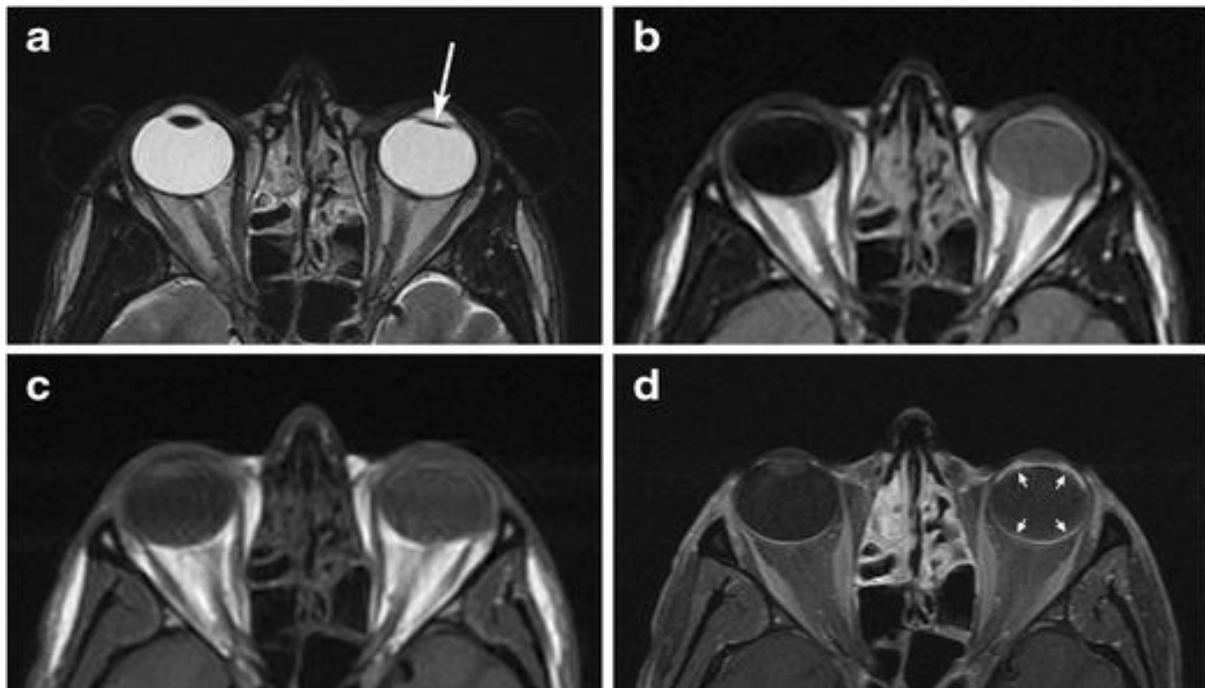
Panuveitis in patients with a - d ankylosing spondylitis. Improved axial T2WI (a), axial (a), FLAIR (b), T1WI (c), and T1WI images in which luma and saturation (d) show a balance between water and glass, and increase the light of gadolinium - Left eye calf groove. The jokes of the left globe are much more dynamic than those of the right in the images with unchanged T1 weight and are surprisingly more intense in the unrevealed FLAIR. There is no significant difference in T2 weight images. The increased brightness of the left ventricular line (arrow) is commendable compared to the normal right eye and the front brightness (c) and post contrast axial (d) images with T1-weighted images. Also noted the formation of cataracts in the left eye (arrow) [17]
